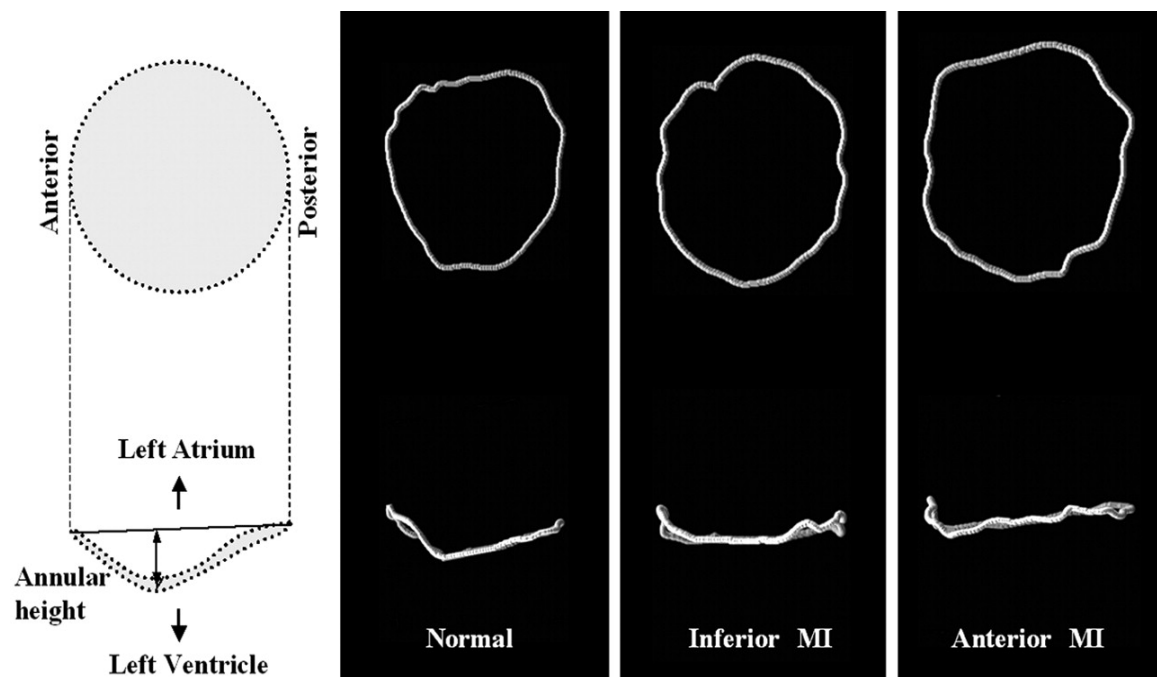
Three dimensional changes in the mitral annular size and shape with different infarct locations as measured from echocardiography. The saddle shaped D configuration of the normal annulus is clearly evident, that is lost with both anterior and inferior myocardial infarction. Maximum dilatation was observed in the anterior infarction case. Figure reproduced from Watanabe et al, *Circulation* 2005, 112, I-458 – 462. [109-111]
